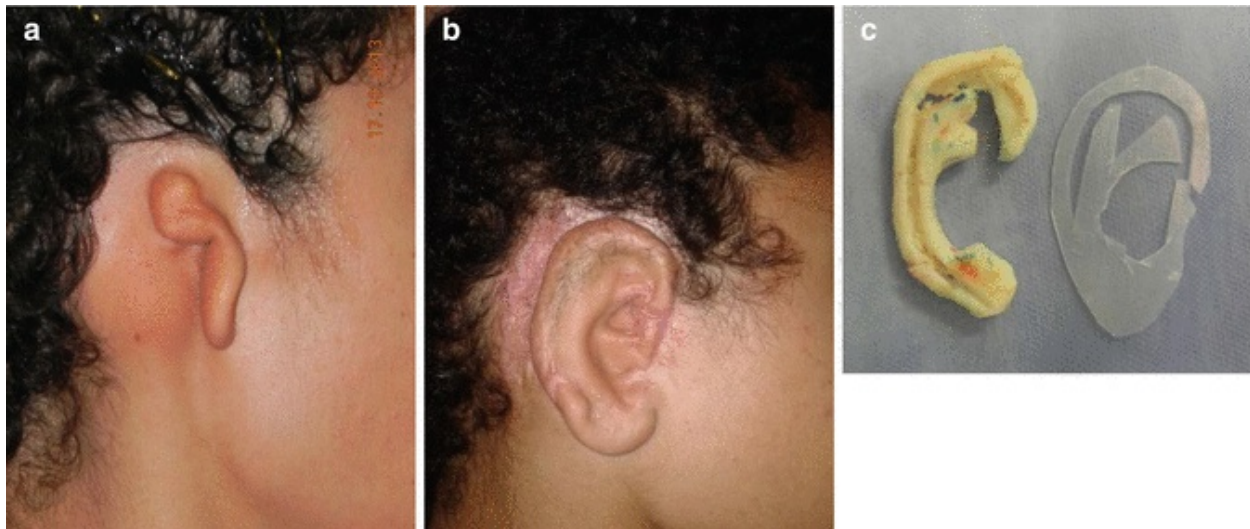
An 8-year-old male patient with severe microtia on the right side. Photo (a) before surgery; (b) 2 years after both stages of ear reconstruction; (c) the new auricular framework excavated on rib cartilage with an X-ray model
